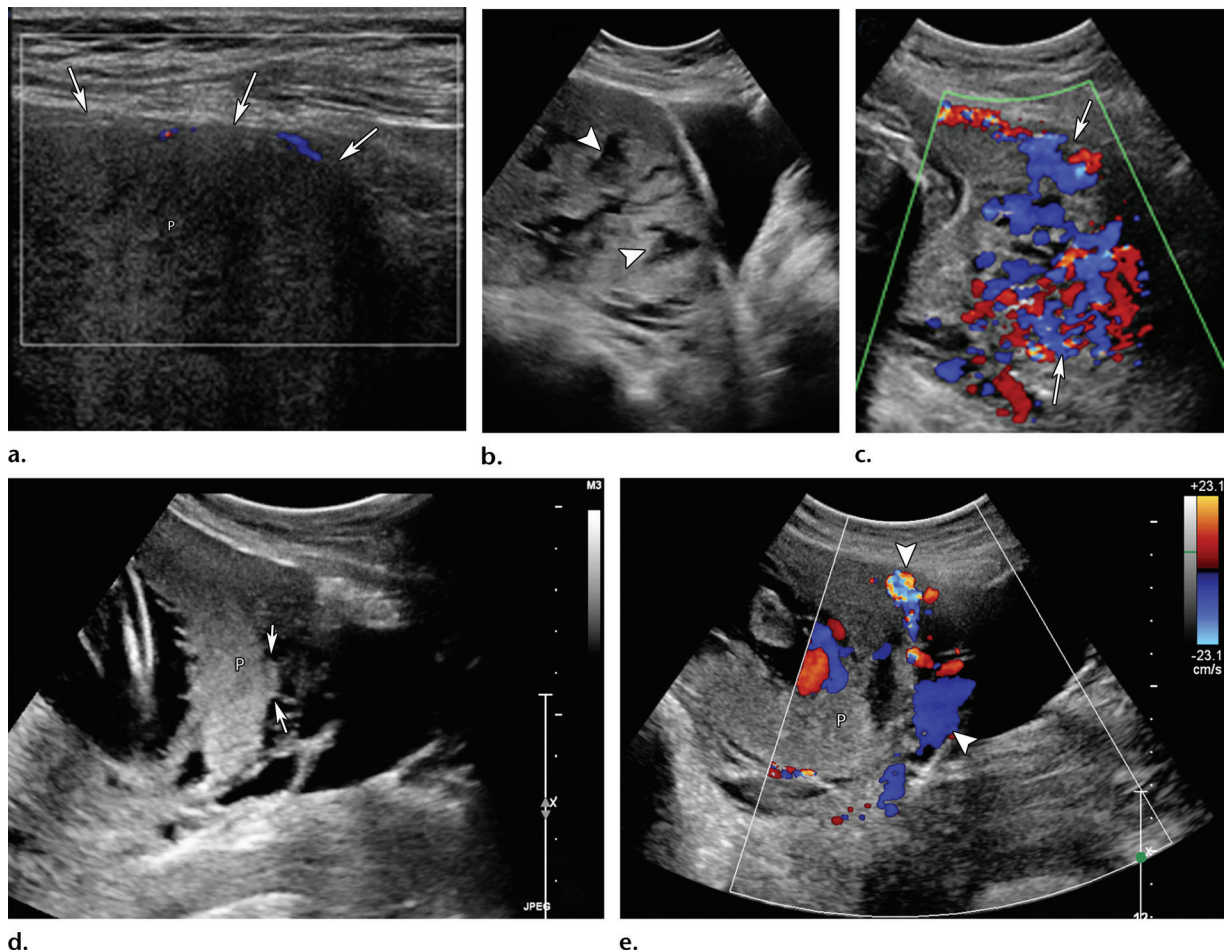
US features of MAP. (a) Myometrial thinning. Longitudinal color Doppler image at 28 weeks gestation shows loss of the normal hypoechoic retroplacental space and reduced thickness of the myometrium (arrows) underlying the placenta (P). (b) Placental lacunae. Longitudinal gray-scale US image of another patient at 29 weeks gestation shows multiple hypoechoic areas (arrowheads) representing placenta lacunae. These had slow blood flow (not shown). (c) Increased vascularity. Longitudinal color Doppler image of placenta increta in another patient at 23 weeks gestation shows increased intraplacental and retroplacental vascularity (arrows). (d, e) Loss of bladder–uterine serosal interface. Sagittal gray-scale US (d) and color Doppler (e) images of another patient at 28 weeks gestation show bulging (arrows in d) of the placenta (P) and bladder, with increased chaotic vascularity along the interface (arrowheads in e).
